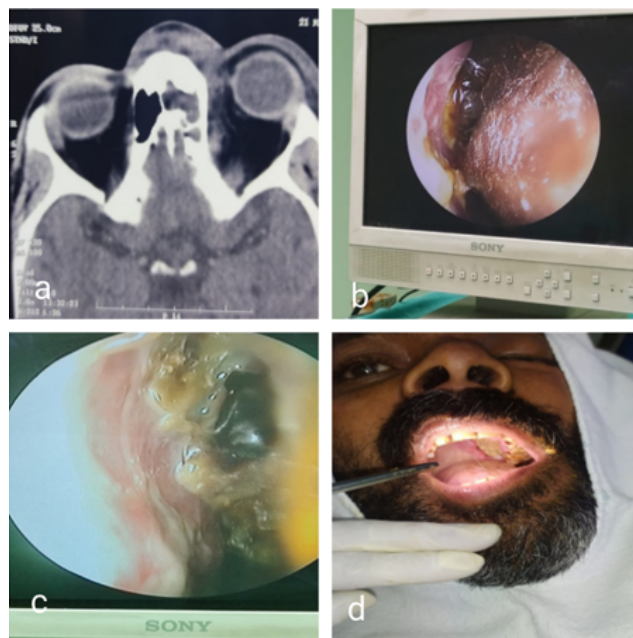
a: MRI of the patient shows moderate edema of the left sided recti muscles and extraconal involvement; b,c,d: Diagnostic nasal endoscopy showed black necrotic tissue/ eschar on middle turbinate, inferior turbinate and bullaethmoidalis with necrosis of hard palate.
